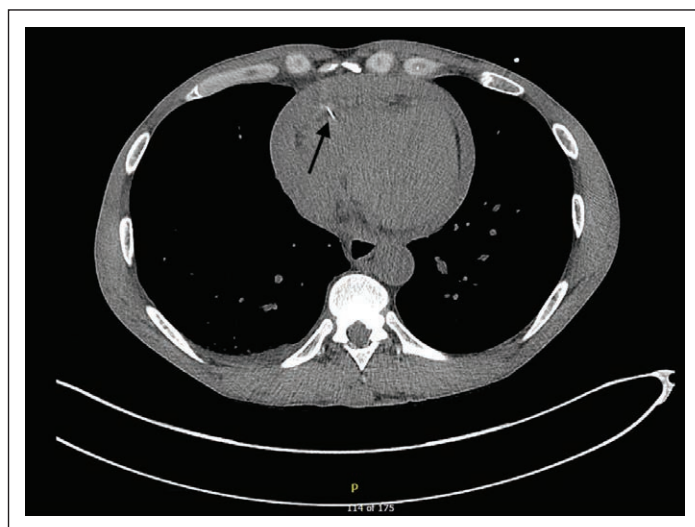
Axial CT chest demonstrating the radio dense needle in the right ventricle penetrating into the pericardial space in the presence of an effusion.
